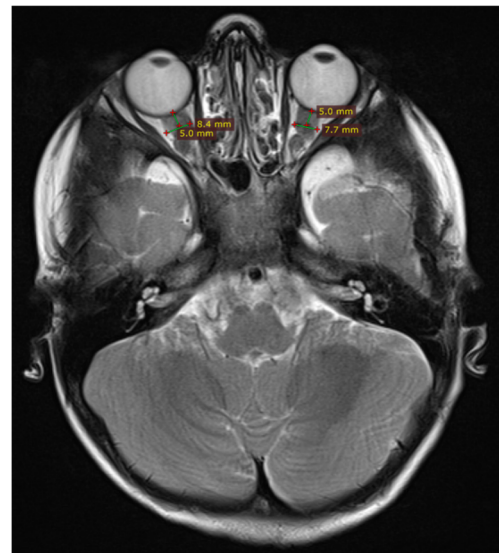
Axial T2-weighted image demonstrates optic nerve sheath enlargement, posterior globe flattening, and intraocular protrusion of optic nerve
